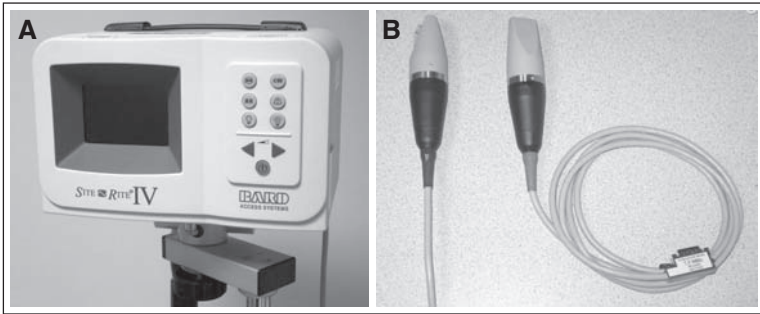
An example of a portable ultrasound unit (Bard) to facilitate vascular access (A) with 7.5 and 9.0 MHz transducers (B).
